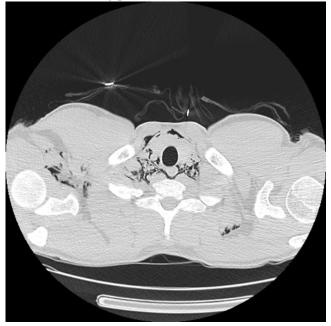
CT of neck, axial view, showing emphysema in the deep spaces of the neck and the right shoulder
